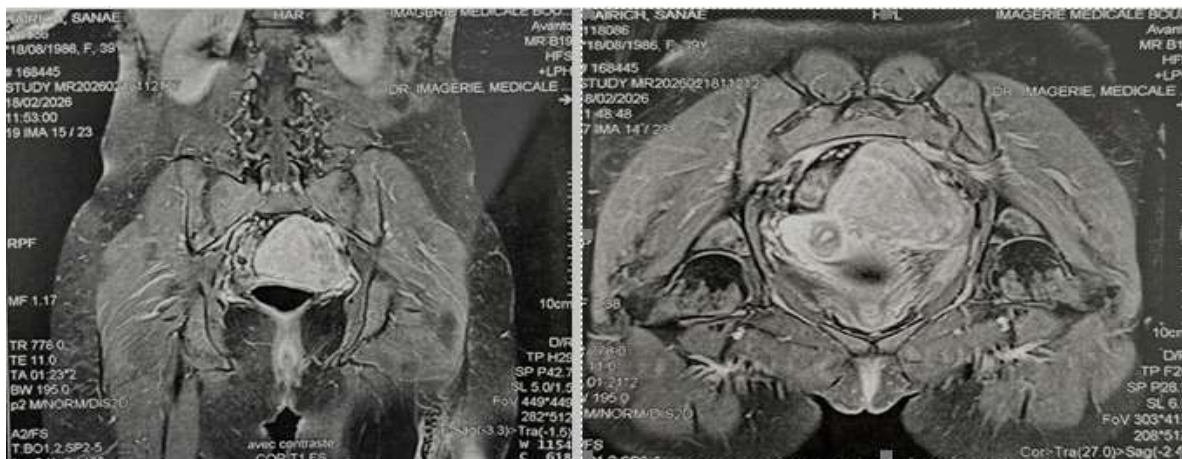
Pelvic magnetic resonance imaging demonstrating a well-circumscribed left adnexal solid mass measuring $108 \times 79 \times 102$ mm, initially interpreted as a benign ovarian fibroma.
